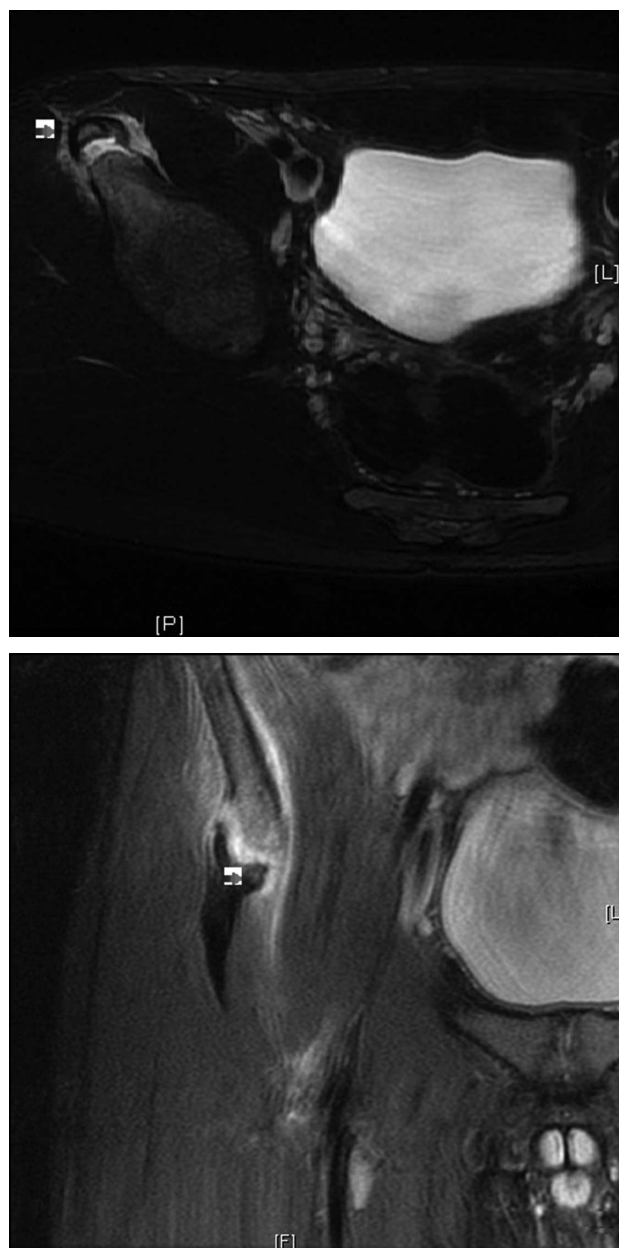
(A) Axial T2-weighted fat suppressed image showing avulsed fragment with arrow. The image shows a fluid collection around the fragment. (B) Coronal proton density fat suppressed image showing the intact rectus femoris and avulsed fragment. Avulsed fragment identified by the arrow.
